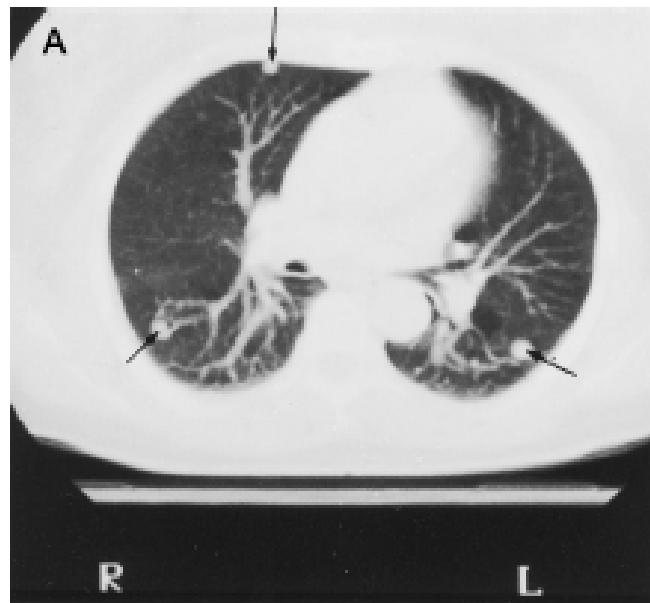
Chest CT in patient 1 demonstrating multiple metastasis before first surgery (A) and free of metastasis 4.5 yr later (B).
